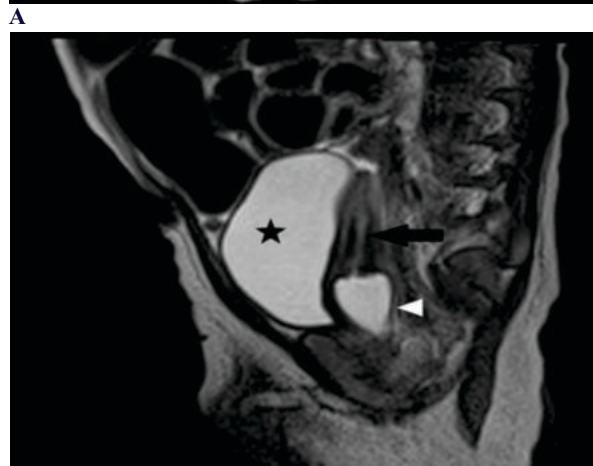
A & B Axial (A) and sagittal (B) MRI pelvis T2 weighted images demonstrates presence of both ovaries with multiple follicles (white arrows), the uterus (black arrow), and fluid filled upper vagina (arrowhead). The lower vagina was not visualized. The urinary bladder (star) Furthermore, those diagnostic tools can even help in diagnosing the primary etiology. (Figures 14-17)
